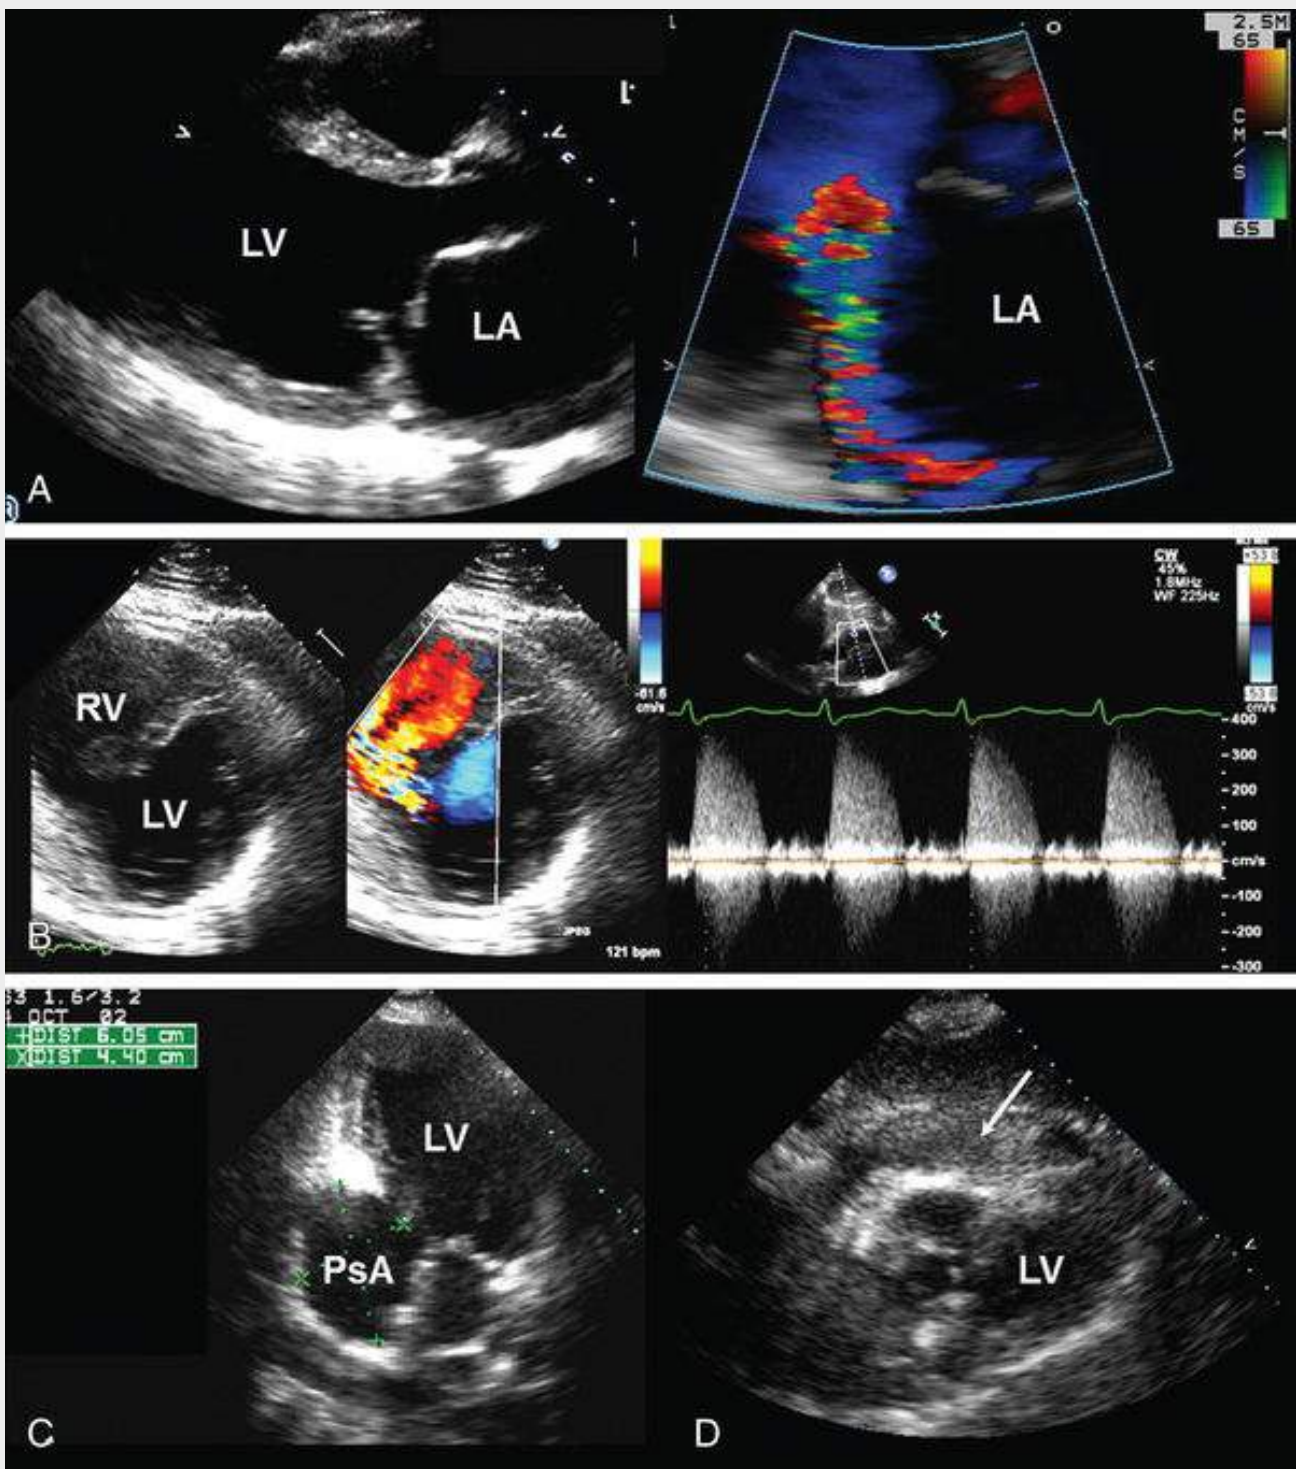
Acute complications of myocardial infarction. A, Flail mitral leaflet (left panel) with severe mitral regurgitation (right panel). B, Ventricular septal defect (left panel) in the basal inferoseptum with (right panel) an intraventricular pressure gradient of 58 mm Hg by spectral Doppler. C, Pseudoaneurysm (*PsA*) of the basal inferior wall. D, Hemopericardium (*arrow*) caused by free wall rupture. LA, Left atrium; LV, left ventricle; RV, right ventricle.
